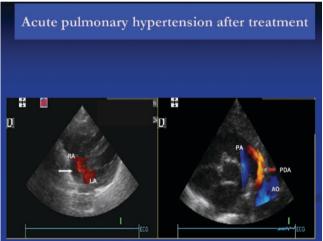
Echocardiography showing significant improvement of pulmonary hypertension after treatment with iNO, with a left-to-right shunt through the foramen ovale (white arrow) and the ductus arteriosus (red arrow)
